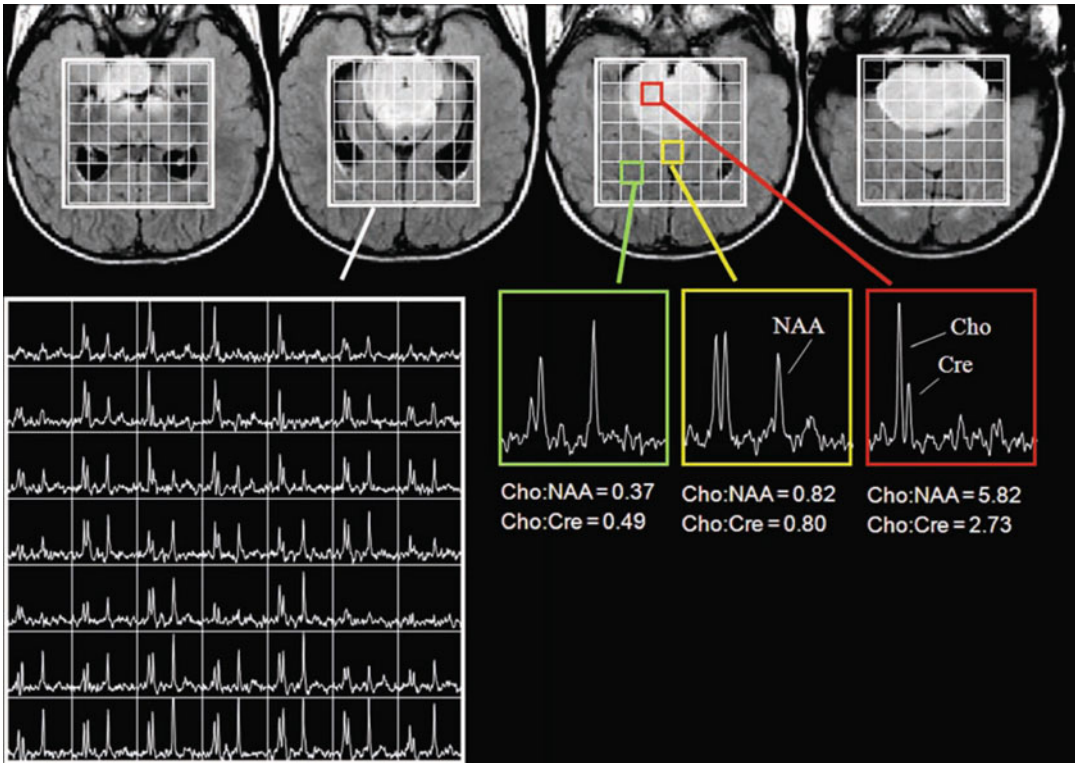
(a–d) Magnetic resonance (MR) images of diffuse pontine gliomas. (a) Axial T1-weighted image contrast. The majority of the lesion is hypointense compared with the normal pons. An irregular area of enhancement is seen within the hypointense center. Many DIPGs do not have any enhancement at presentation. (b) An axial T2-weighted image. The lesion is hyperintense, demonstrating the large area of involvement with preservation of the internal structure of the pons. (c) A FLAIR image
